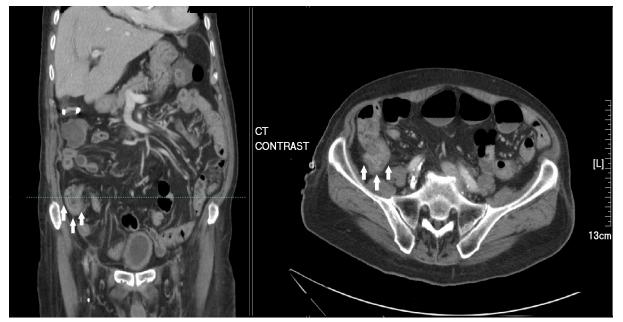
Computed tomography (CT) of the abdomen showed thicken bowel wall in the right lower abdominal space. (arrow)
